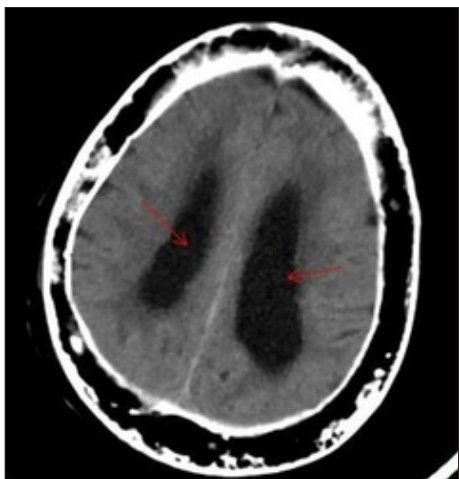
Axial CT image showing dilated ventricles (red arrows)
